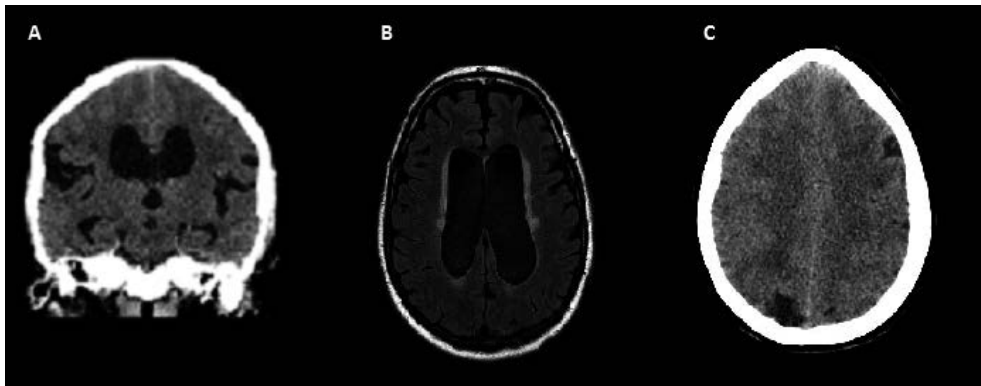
(A) Dilated Sylvian fissures and temporal horns. (B) Periventricular white matter hyperintensities on MRI. (C) Isolated dilated sulci.
